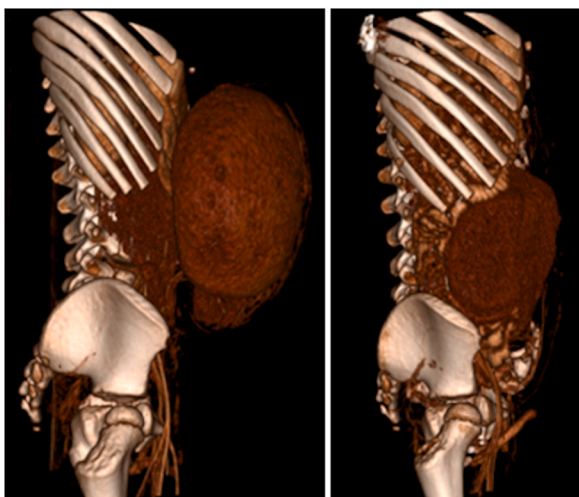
Preoperative (left) and postoperative (right) computed tomographic imaging obtained immediately prior to the second stage of reconstruction. The abdominal domain has naturally expanded following reduction of the visceral contents.
